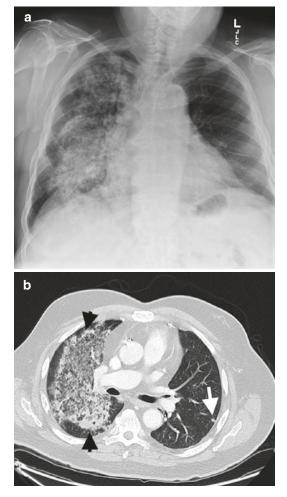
Patients with known GPA presenting with acute hemoptysis. (a) PA CXR with new parenchymal opacification right lung and (b) axial CT lung windows with diffuse right-sided airspace opacification (*black arrowheads*) in keeping with acute hemorrhage in this case, note subpleural nodule left lung (*arrow*)
